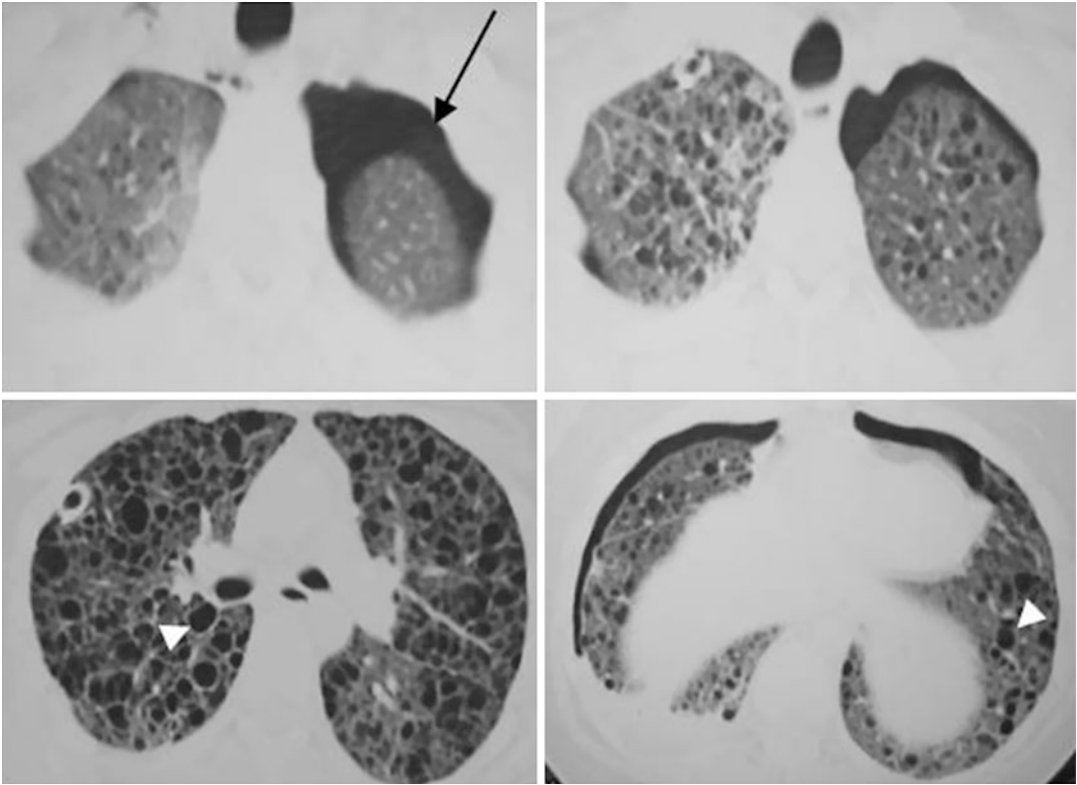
Chest CT findings of lymphangioleiomyomatosis. Serial sections throughout the chest demonstrate diffuse parenchymal involvement. *Black arrow* denotes
